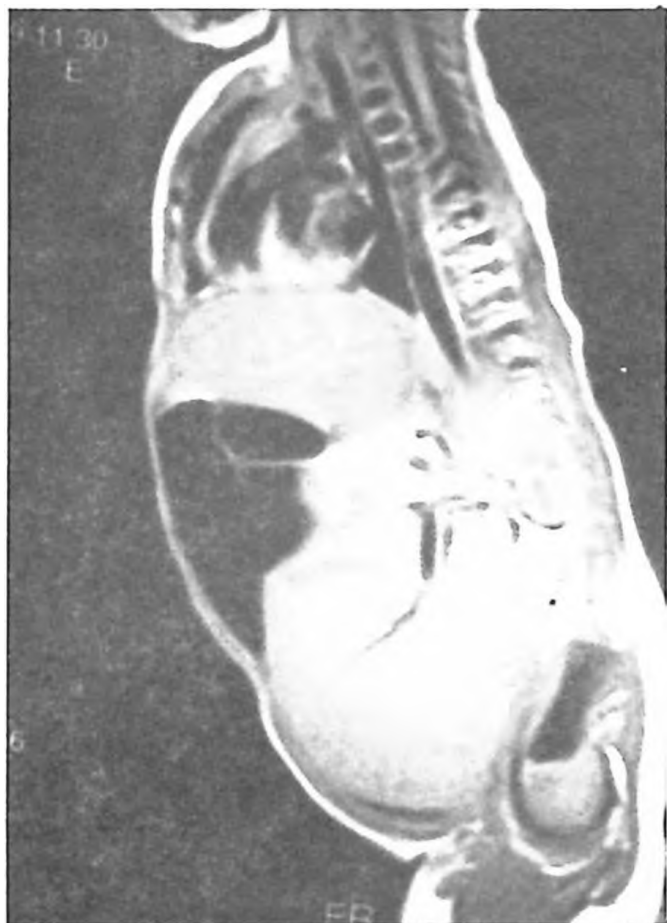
Pelvic ectopic spleen and its vascular structure in magnetic resonance imaging (sagittal section).
